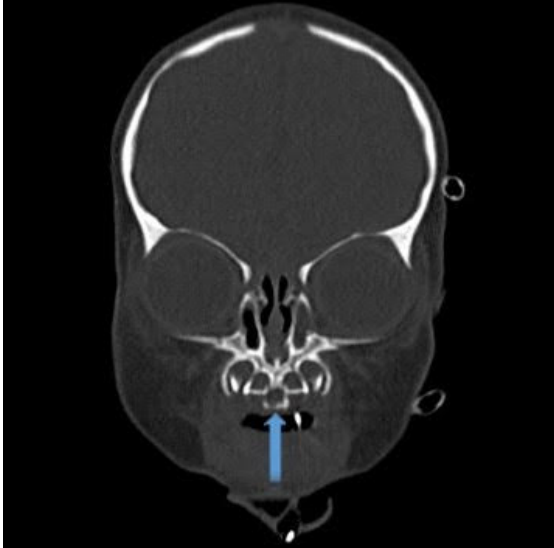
A coronal maxillofacial CT scan of a newborn with CNPAS that reveals a solitary maxillary central incisor (blue arrow). Image from: Burch JL, Whitesel E, Manzi B, Adil E. A neonate with obstructed nasal breathing. *Neoreviews*. 2023;24(3)e195.10.1542/neo.24-3-e195
